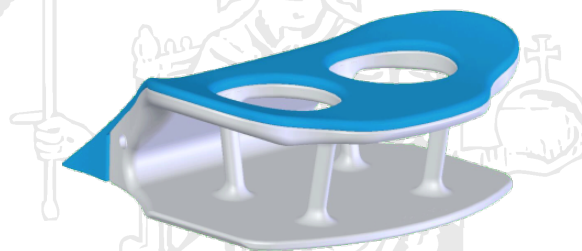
A model of breast-coil used in DCE-MRI
